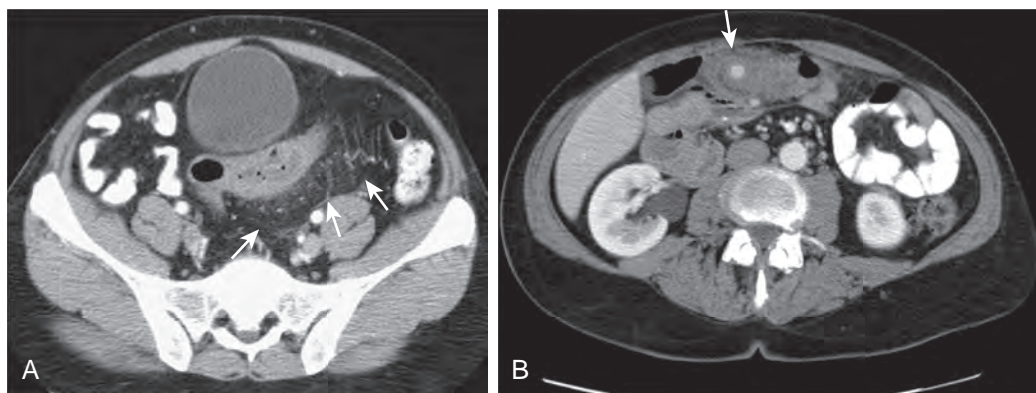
MDCT of diverticulitis: early changes. A. Axial CT scan of the sigmoid colon demonstrates mural thickening with haziness of the sigmoid mesocolon (arrows) associated with engorged vasa recta. B. Axial postcontrast CT scan shows mural thickening and pericolic inflammatory change in the transverse colon, with hyperdense diverticulum (arrow).
